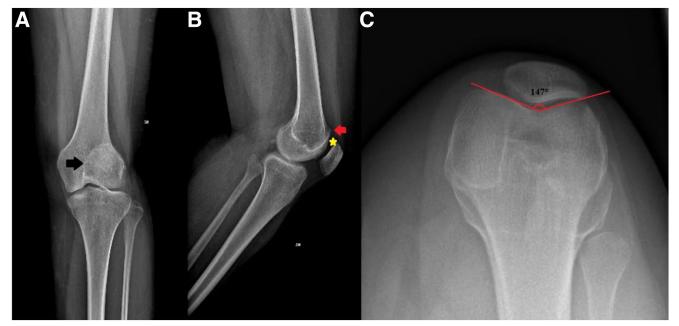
Left knee. (A) Anteroposterior preoperative left knee radiograph showing patellar lateralization (black arrow). (B) True lateral preoperative radiograph demonstrating a dysplastic femoral trochlea characterized by crossing sign (yellow star) and a supratrochlear spur (red arrow). (C) Preoperative patellar sunshine-view radiograph showing patellar lateralization and a slightly increased sulcus angle of 147° (red angle).
